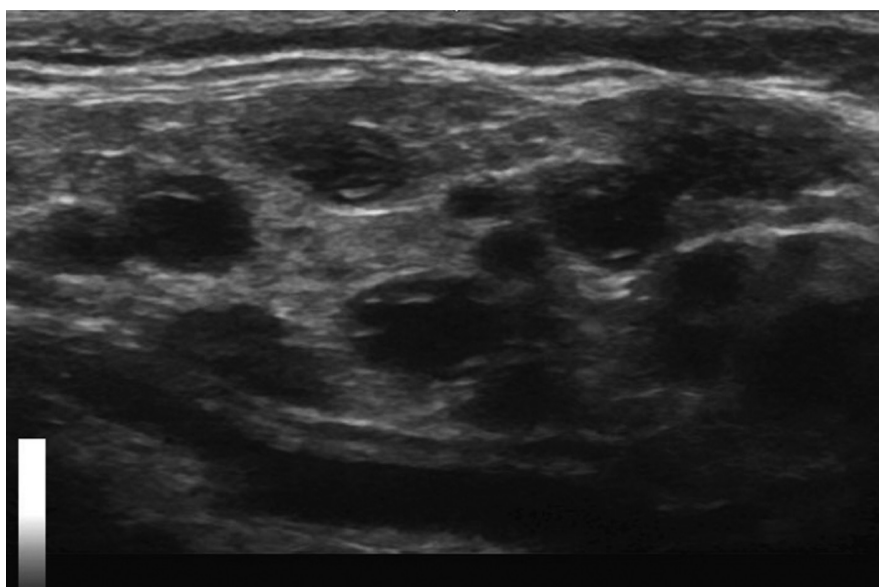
Longitudinal ultrasound image of a parotid gland showed multiple hypoechoic cysts and dyshomogeneous gland parenchyma.
